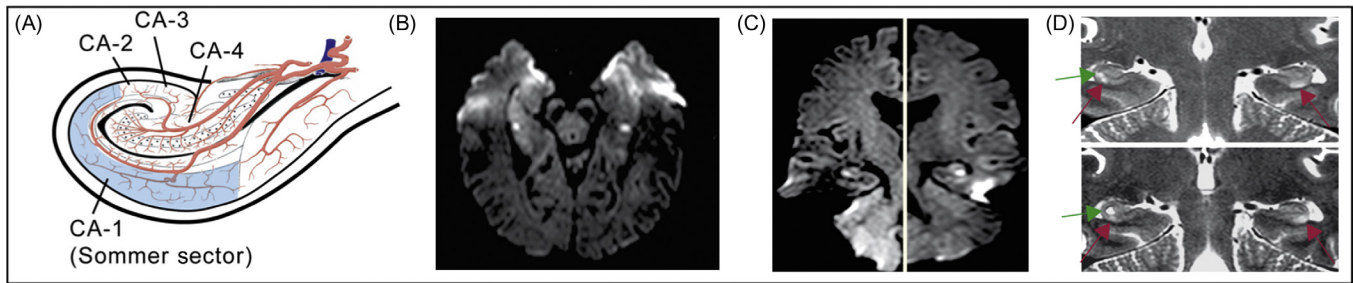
Magnetic resonance imaging in transient global amnesia. (A) Hippocampal subfields; (B)–(D) Typical lesions seen in the hippocampus within 48 h after onset on axial and coronal diffusion weighted and T2 weighted sequences, respectively. Note in this case the bilateral T2 lesions in the CA-1 sector of the cornu ammonis (red arrow) extending over 4–5 mm (slice thickness 2 mm) which are clearly separated from the cavity of the pre-existing vestigial hippocampal sulcus (green arrow) located in deeper subcortical layers in the vicinity of the gyrus dentatus (Bartsch et al., 2006). Source: Reproduced with permission of Oxford University Press.
